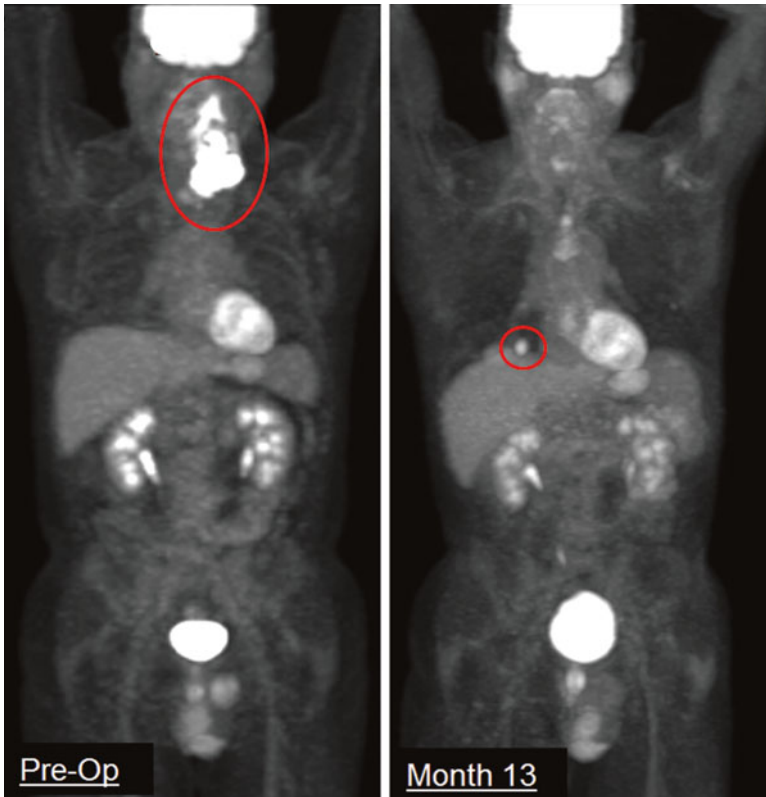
Preoperative and month 18 FDG-PET whole-body imaging of the presented patient. Areas highlighted in red indicate observed macroscopic disease at each time point
